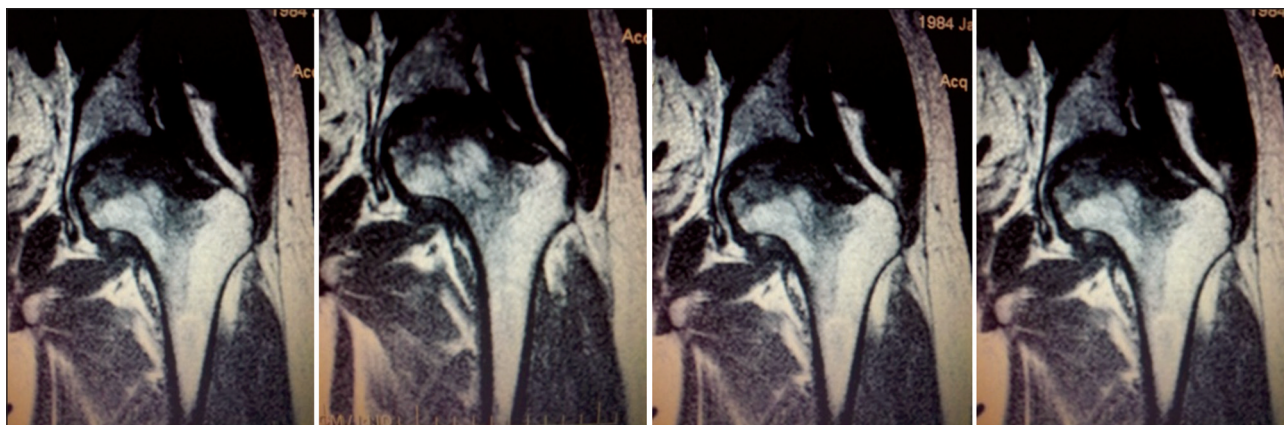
MRI image of avascular necrose of the patient
